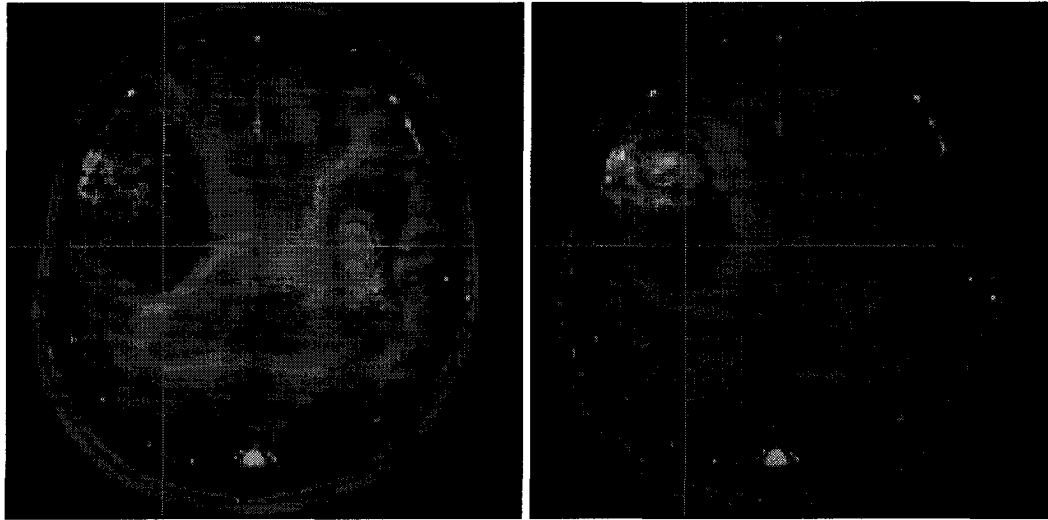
MRSI biochemical concentration images superimposed on the corresponding anatomical MR image. High choline concentration (left) indicates area of hyper-cellularity, whereas low N-acetylaspartate (NAA) concentration (right) in the tumour area indicates lack of viable neuronal tissue.
